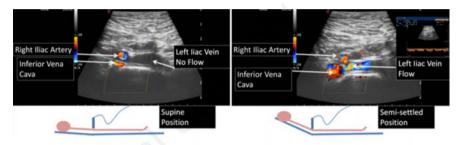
The semi-settled 45° position to assess the presence of illusory May Thurner syndrome at ultrasounds performed in supine position.
